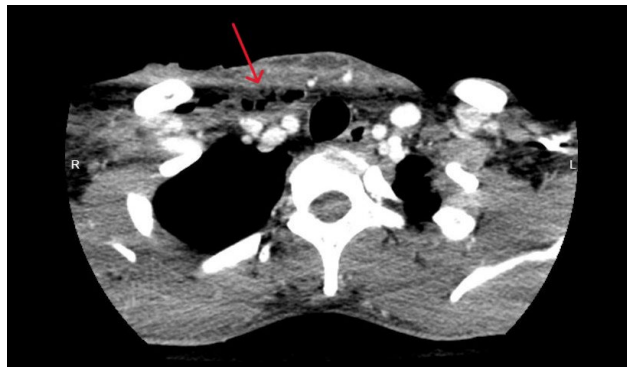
CT image in the axial view showed hypodensity of the anterior chest with air within the collection (red arrow), and extending to the anterior chest
